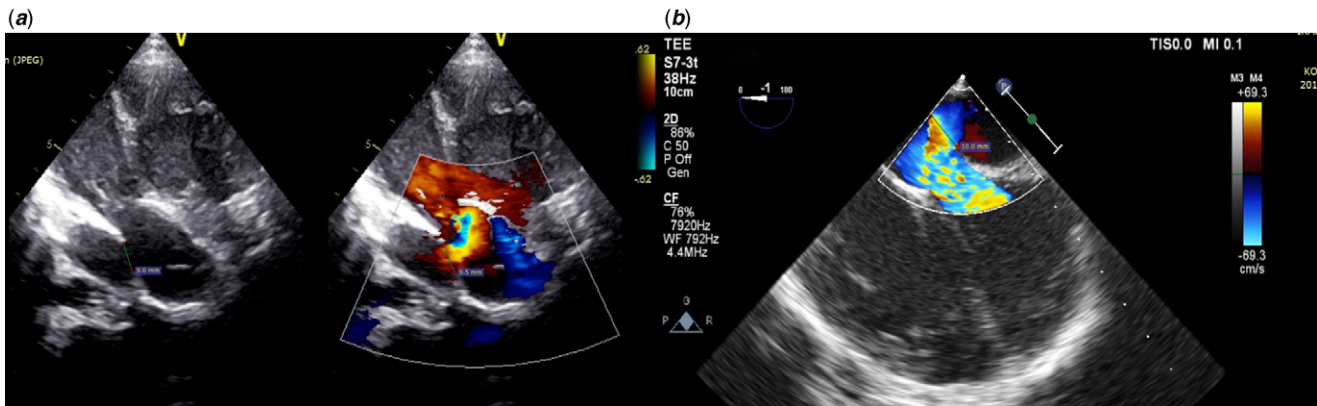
(a and b) Transthoracic echocardiography showed mild tricuspid regurgitation and a defect of 9 mm in width with a left-to-right shunt between the pulmonary and systemic venous baffle. The size of the defect was measured as 10 mm on transoesophageal echocardiography.
